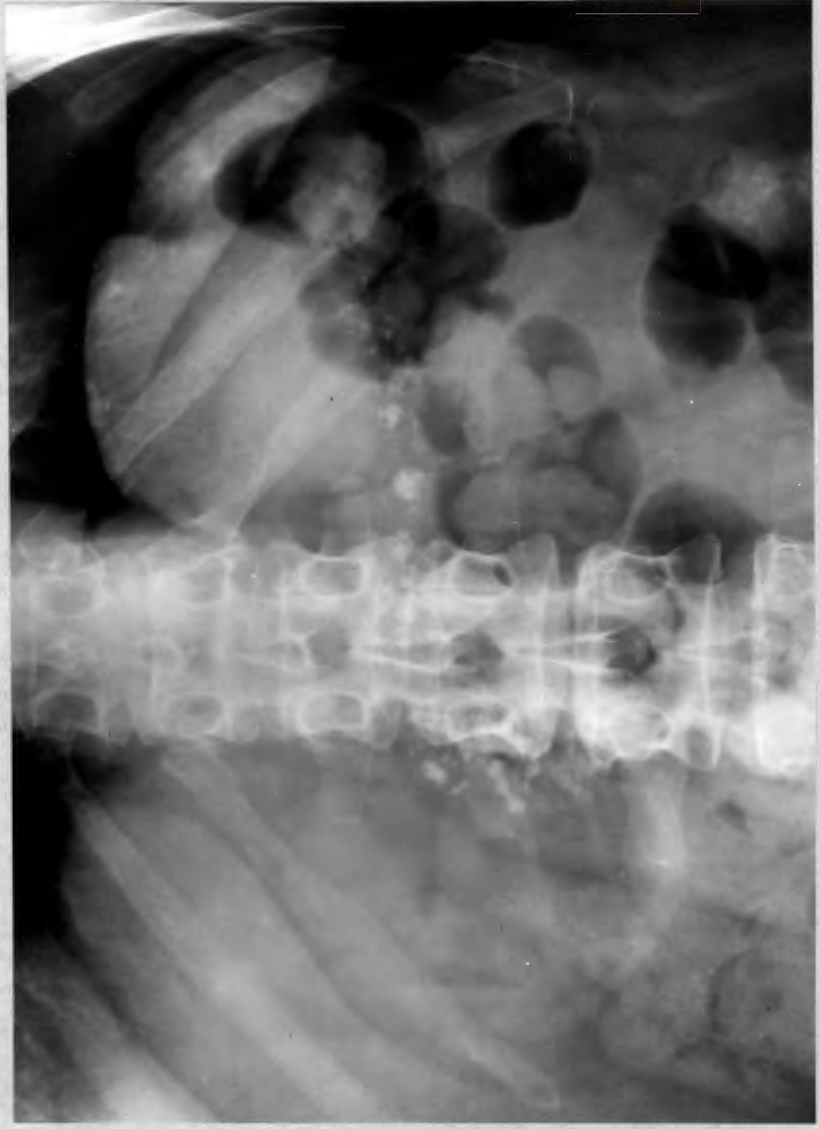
Photograph of an abdominal x-ray in the patient in Fig. 3.16a showing the pancreatic calcification.
